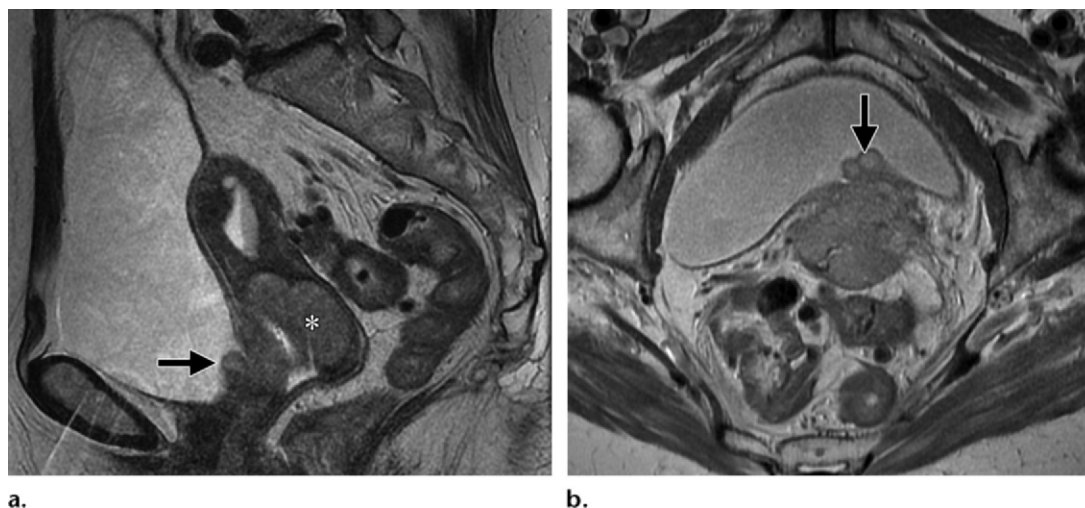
Stage IVA cervical carcinoma (adenocarcinoma) in a 76-year-old woman. Sagittal (a) and axial (b) T2-weighted MR images show a cervical tumor (*) with intermediate signal intensity and nodular local invasion into the bladder (arrow).
